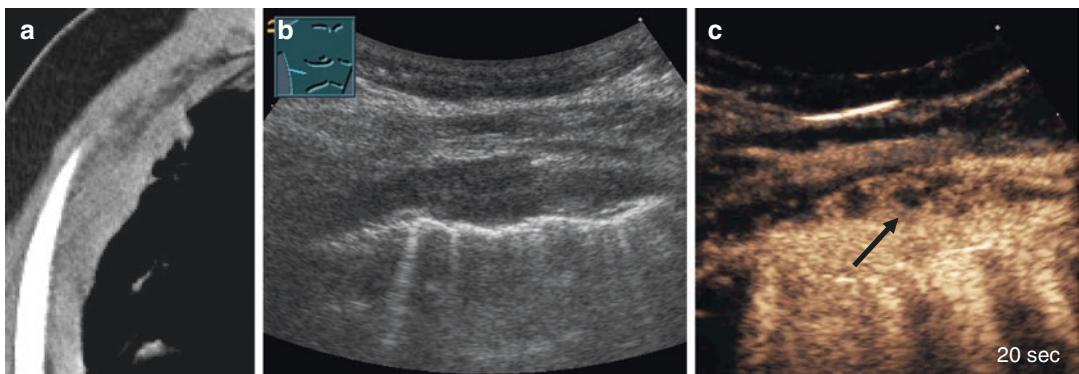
Patient with fever and a right-sided pulmonary consolidation on X-ray examination (a); B-mode imaging shows an oval well-demarcated hypoechoic pleural lesion (b); on CEUS the lesion shows a marked wall enhancement and no central enhancement (c). Further investigation confirmed diagnosis of *pleural empyema*
